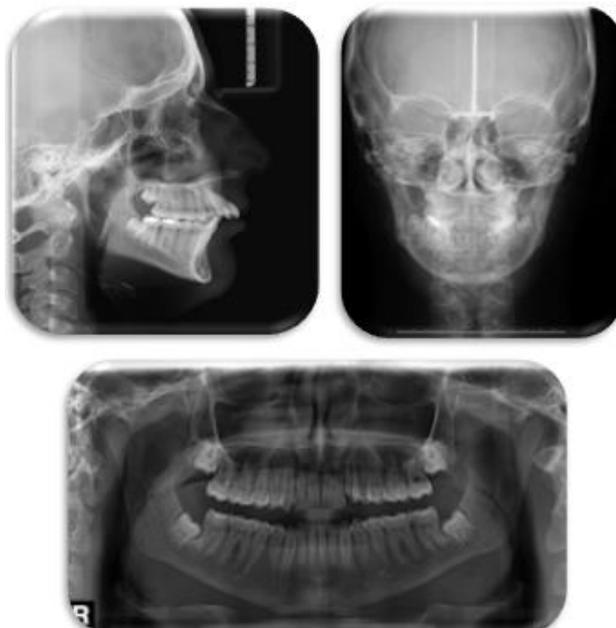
Pretreatment lateral, posteroanterior cephalometric and panoramic radiographs
